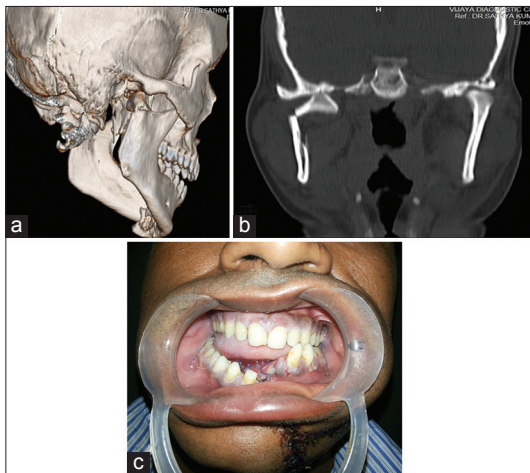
(a) Displaced and dislocated condylar fracture on a reconstructed CT scan (b) Coronal section CT showing antero-medially displaced and dislocated condylar neck fracture and telescoping of the ramus superiorly due to pterygomasseteric pull (c) Preoperative clinical picture showing severely deranged occlusion due to grossly displaced fractures of mandibular condyle, symphysis and anterior dentoalveolar region
